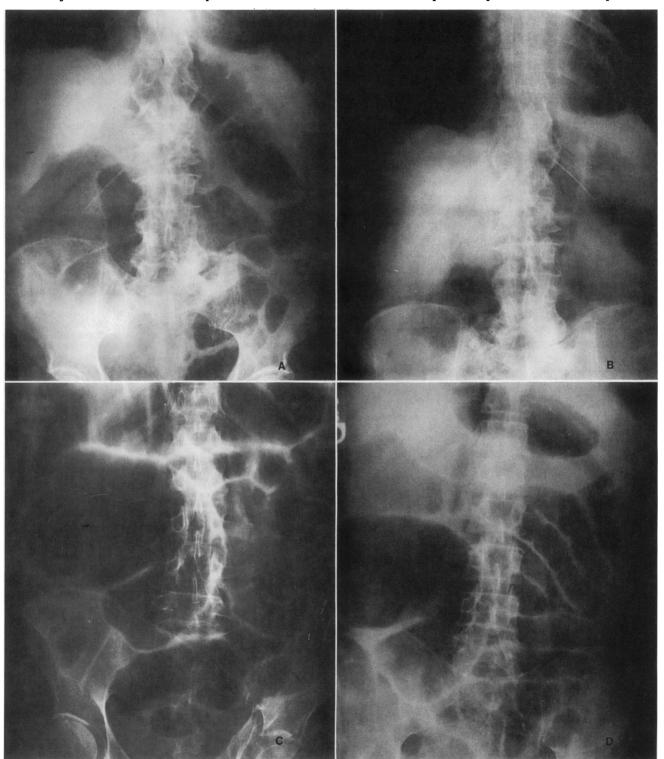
Representative abdominal roentgenograms of two patients before (A and C) and immediately after (B and D) successful colonoscopic decompression.
